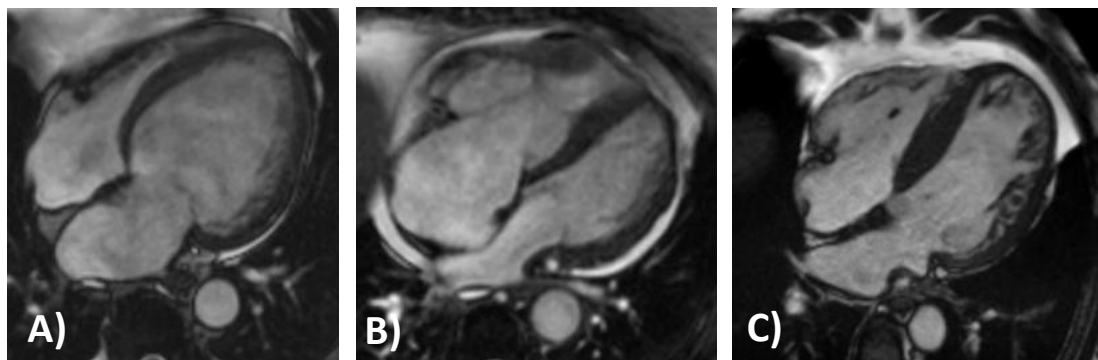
Different forms of secunder hypertrabeculation on long-axis four-chamber CMR images. Image (A) presents dilated cardiomyopathy with dilated left ventricular cavity and thinned wall; image (B) describes arrhythmogenic cardiomyopathy with dilated, fatty infiltrated right ventricle; and image (C) shows hypertrophic cardiomyopathy with thickened left ventricular wall. CMR = cardiac magnetic resonance imaging. Images belong to the Semmelweis University, Heart and Vascular Center.
